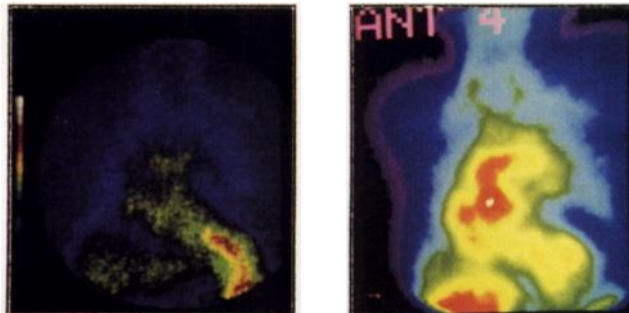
Left ventricular thrombus. This patient had a very large left ventricular thrombus, which measured approximately 9.0 cm across by two-dimensional echocardiography. Platelet imaging showed a large area of definite uptake onto an apical left ventricular thrombus, visually graded as 3. In contrast, antifibrin imaging at all times was negative (visual grade = 0). The location of greatest antifibrin activity was the overlap of the atria and outflow tract vessels, but no increased uptake was present in the area of the thrombus at the cardiac apex.
